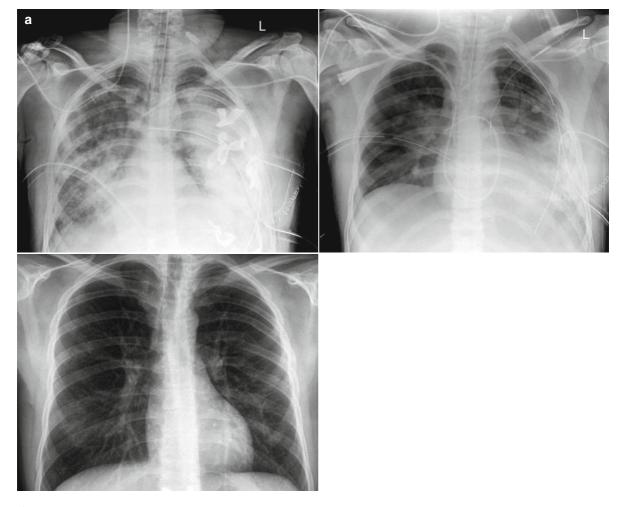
(a) Severe chest trauma: Sequence of chest radiographs. (b) Patient with PECLA (Pumpless ExtraCorporal Lung Assist)
